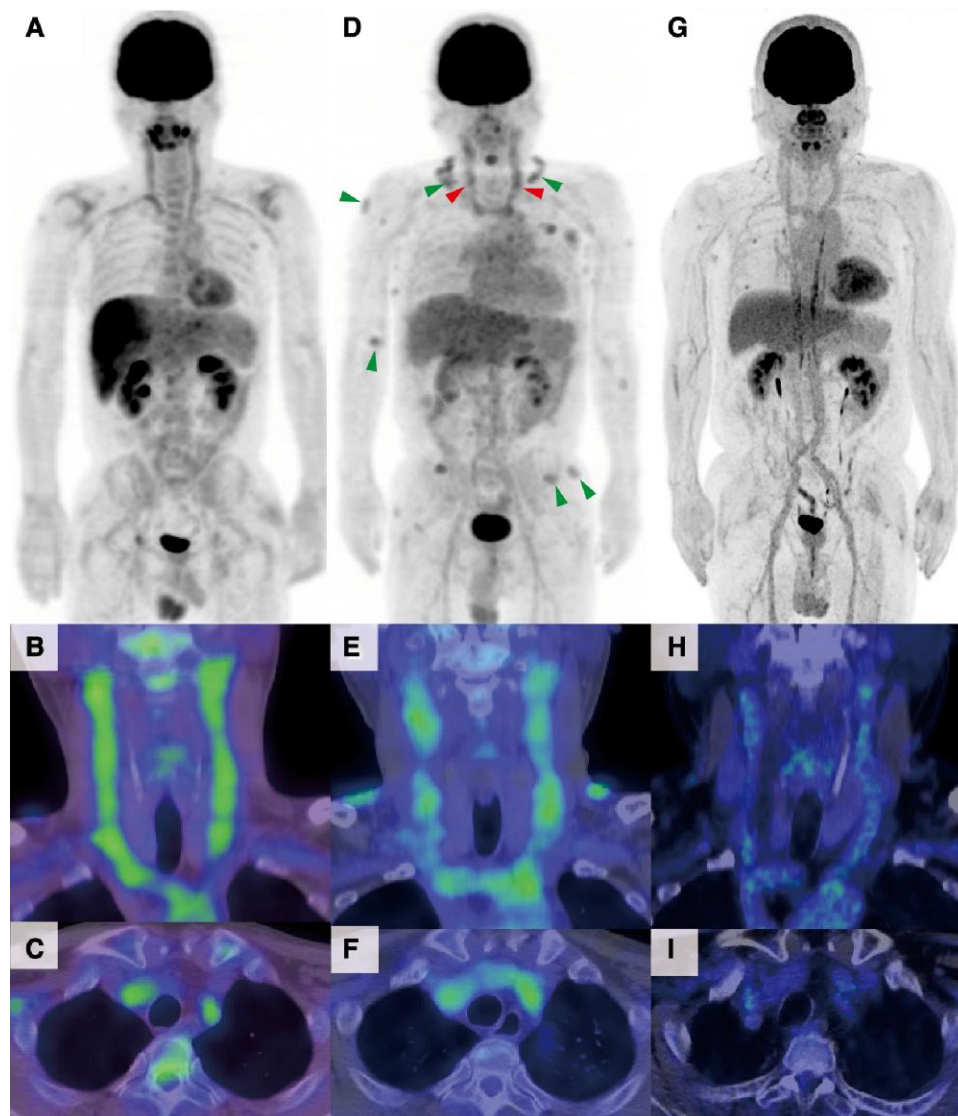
(A–C) Positron emission tomography/computed tomography 10 years before diagnosis. A total of 223 MBq of ^{18}F -fluorodeoxyglucose was administered (5-h fasting). (A) The maximal intensity projection showed fluorodeoxyglucose uptake in bilateral common carotid arteries (maximum standardized uptake value: SUVmax 3.2). (D–F) Positron emission tomography/computed tomography on admission. A total of 275 MBq of ^{18}F -fluorodeoxyglucose was administered (20-h fasting). (D) The maximal intensity projection showed fluorodeoxyglucose uptake in bilateral common carotid arteries (SUVmax 3.1, red arrowhead) and fluorodeoxyglucose uptake corresponding to the skin lesions (green arrowhead). (G–I) Latest positron emission tomography/computed tomography after 296 MBq of ^{18}F -fluorodeoxyglucose was administered (5-h fasting). (G) The maximal intensity projection showed dampened uptake in bilateral common carotid arteries and skin lesions. (B, E, H) Coronal section of the carotid arteries. (C, F, I) Axial section at the level of the brachiocephalic trunk.
